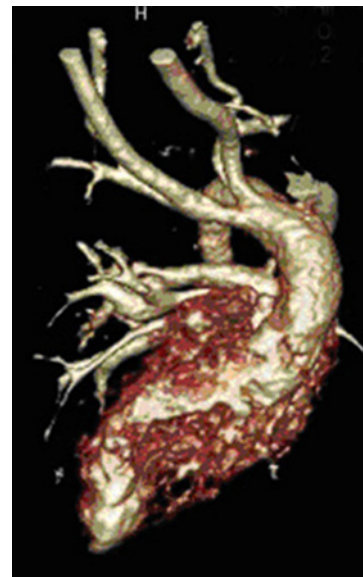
Four months old boy that aortic arch was not visualized with echocardiography. MDCT was requested to determine anatomy of aortic arch consist of right sided aortic arch and anomalous arch branches. VRT from anterior view.
